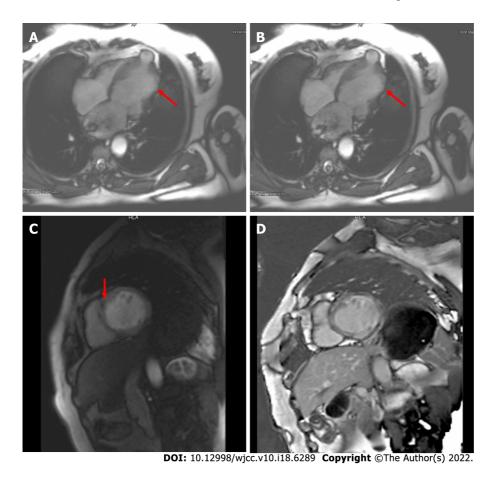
Cardiac magnetic resonance imaging results of the patient under this study. A and B: Four-chamber cine images at end-diastole (A) and end-systole (B) showed left ventricular dilatation, abnormal activity of the ventricular wall (arrows indicate severely diminished contractility), and outpouching at the left ventricular apex; C: Short-axis first-pass perfusion showed a low signal at the midwall of the septum myocardium; D: Short-axis delayed enhancement imaging demonstrated diffuse stripes of hyperenhancement in the midwall of the left ventricular septum and free wall myocardium.
